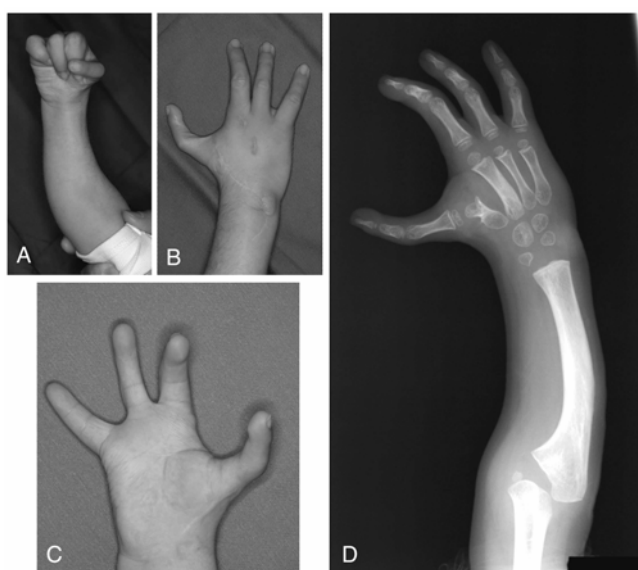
A–D, The patient at 58-months-old. At 36 months after centralization (27 months after pollicization), an X-ray film demonstrates a change in the distal contour of the ulna, with widening and cupping to support the carpus, so that it resembles a normal radius. Good functional and cosmetic results were obtained.
